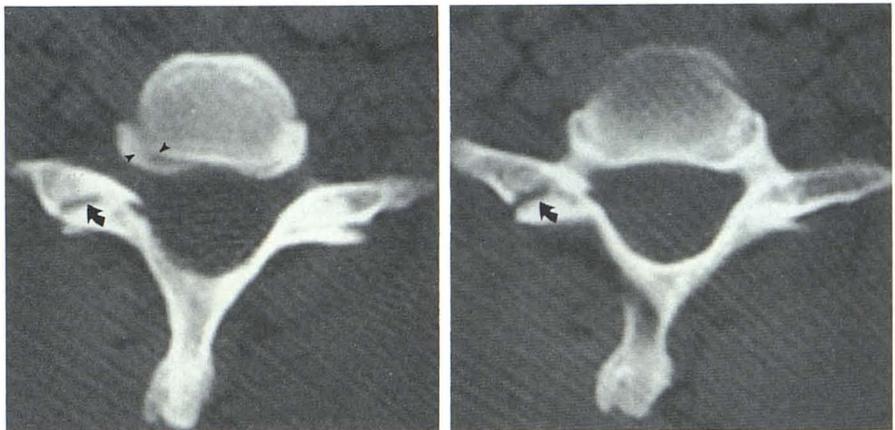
Consecutive CT sections through articular pillar fracture. Fracture line (*arrow*) could be misinterpreted as a joint, especially if lower-resolution images were obtained. Slight uncovertebral joint subluxation (*arrowheads*).
